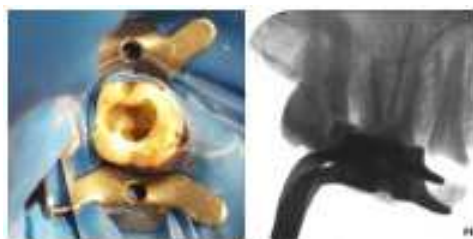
Obturation's Radiograph
